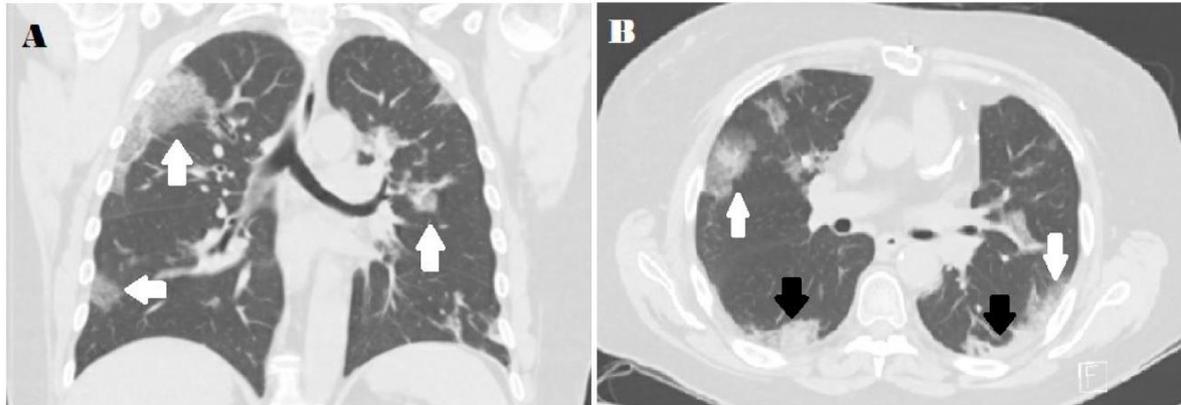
CT images of COVID-19 patient showing ground-glass opacities
